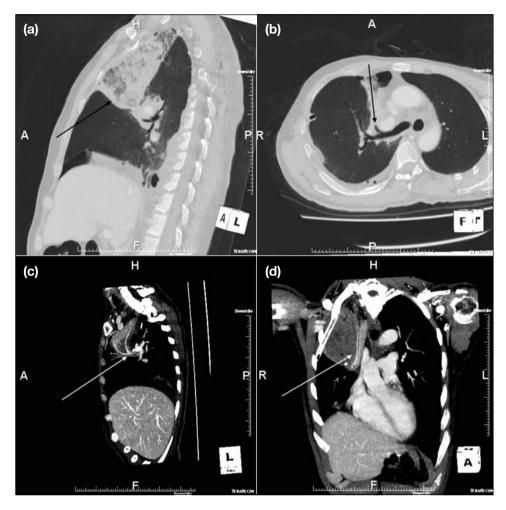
Case 1. Selected computed tomography images showing (a) collapsed right middle lobe with poor contrast enhancement and mottled appearance; (b) tapered right middle lobe bronchus; and (c, d) right middle lobe pulmonary artery small in calibre and curving in an abnormal configuration.
